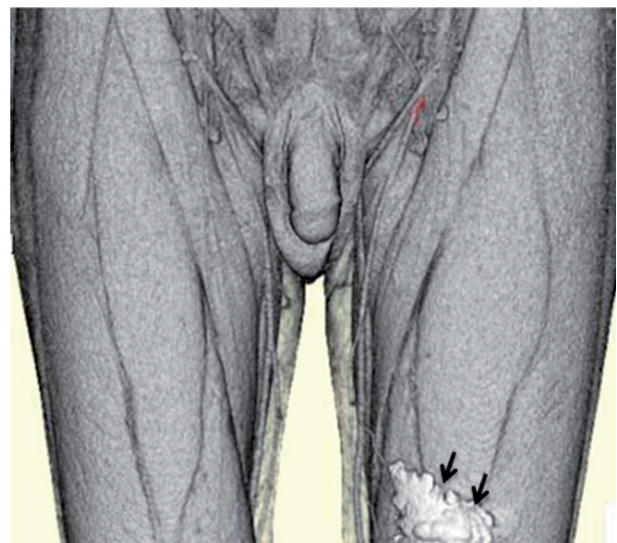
Sentinel lymph node (red colour; since the colour was faint it was converted into red) detected by 3-dimensional computed tomography image with iopamidol in patient 6 (arrows: the remains of the contrast medium injected at the site of the tumour).
